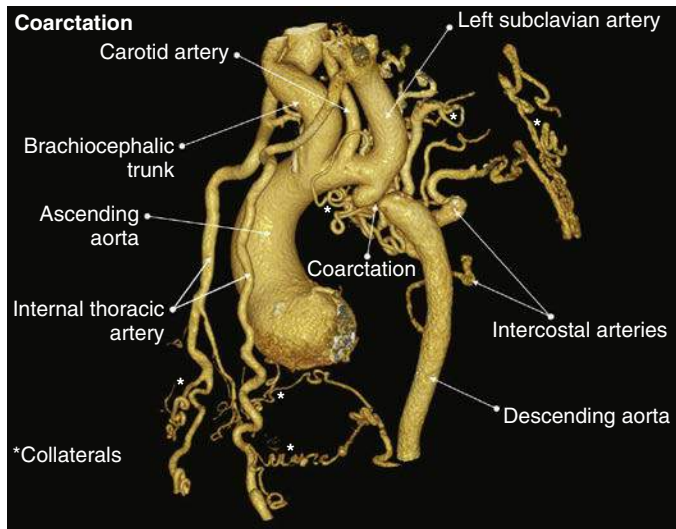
Magnetic resonance image of an adult with native aortic coarctation showing anatomic details of the thoracic aorta, the coarctation, and marked collateral circulation. (Courtesy C. Meierhofer and C. Pankalla, German Heart Center, Munich, with permission.)
